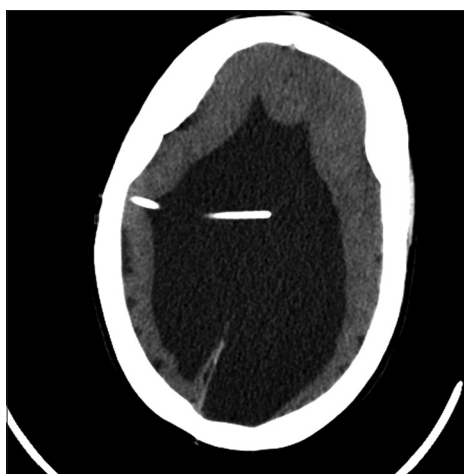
Computed tomography brain without contrast showing ventriculomegaly with an interventricular shunt. Also noted are callosal dysgenesis and absent septum pellucidum
